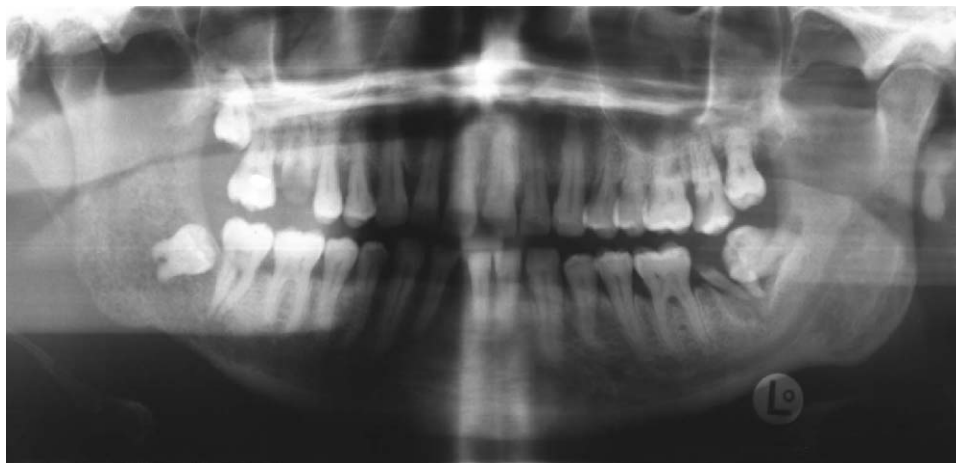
Panoramic radiograph of a 48-year-old male smoker showing metastatic lung cancer to the right mandible.
